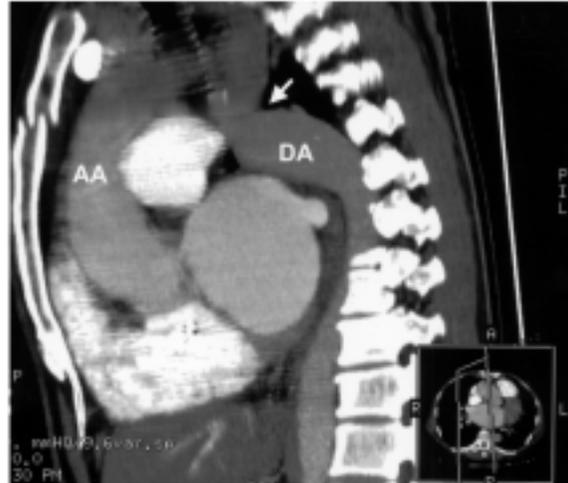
Three-dimensional chest computed tomography showed coarctation of aorta. AA = ascending aorta, DA = descending aorta.
